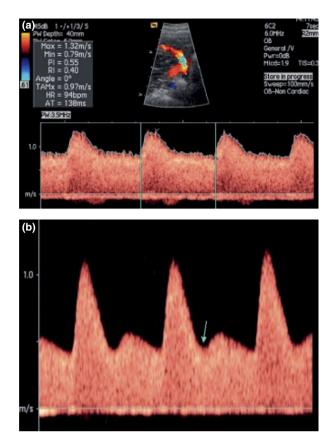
Second trimester uterine artery Doppler waveforms. (a) Normal; (b) abnormal.¹² Reproduced with permission. © 2013 ISUOG.
